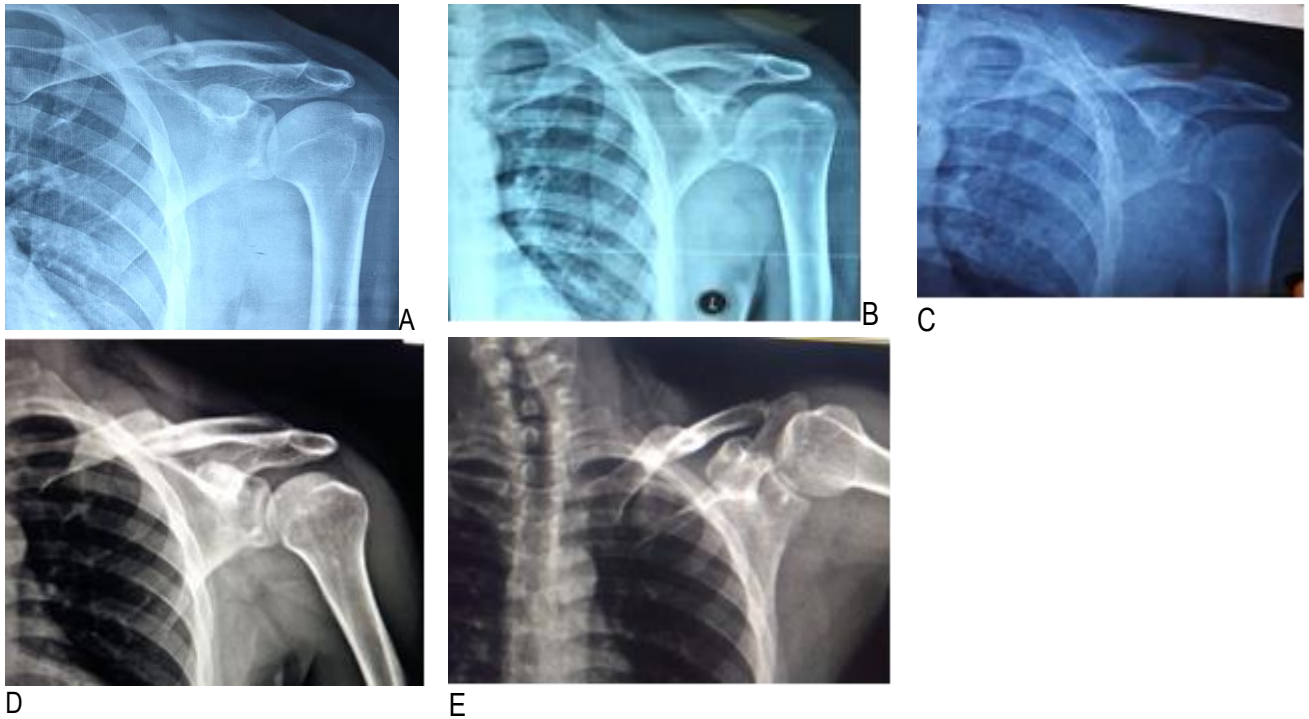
The first patient treated conservatively: here are the x-rays at the first day of trauma (A), One (b), Two (C), Four (D) and Sixth (E) months after treatment
